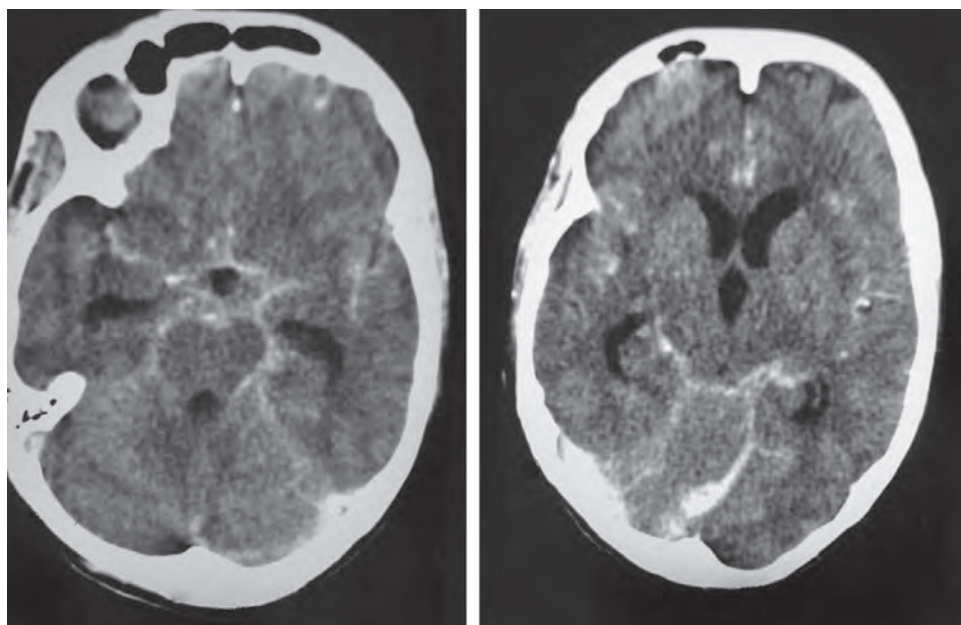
CT scan of the brain showing post-contrast enhancement of the basal exudates
